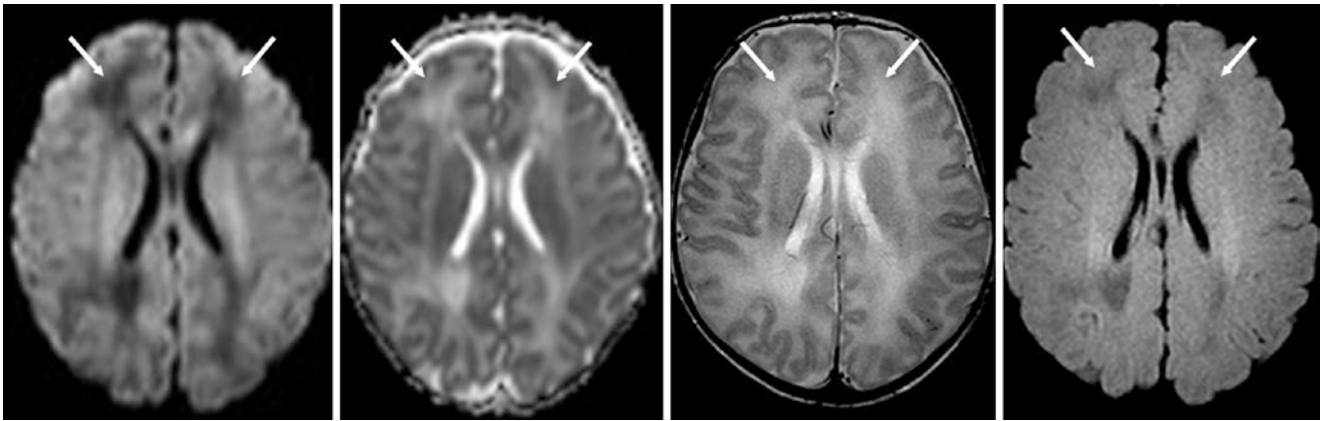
A 1-month-old term infant with difficulty breathing at birth (no imaging at that time) had a normal 3T MRI. On DWI (*left*), there was patchy low signal (*arrows*) in white matter areas that are bright on
